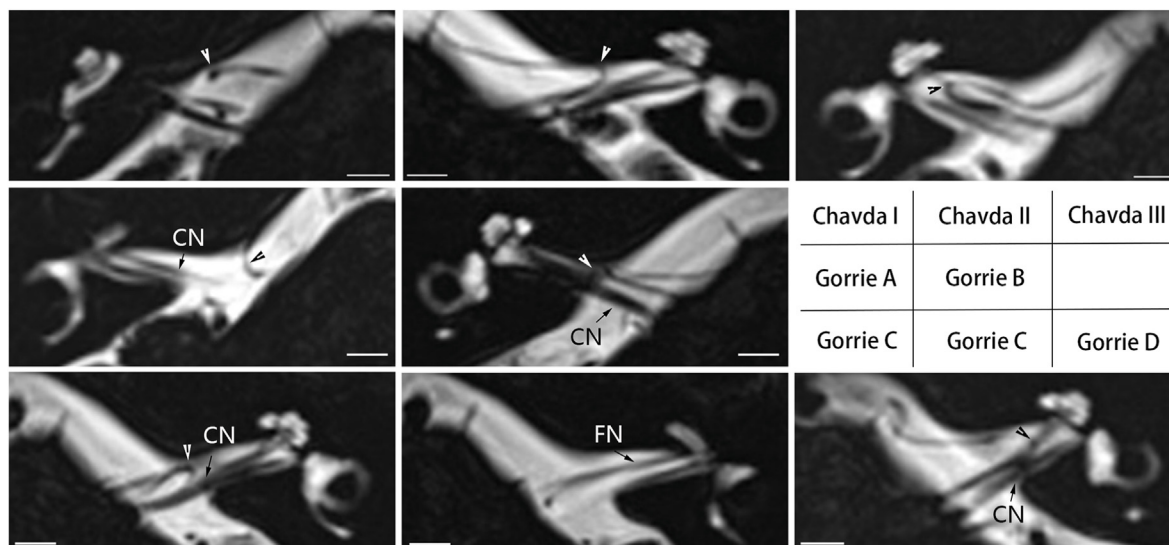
Representative MRI demonstrating the Chavda and Gorrie classifications of the anterior inferior cerebellar artery (AICA). The distal point of the AICA is indicated with an arrowhead. CN: cochlear nerve; FN: facial nerve. Scale bars = 5 mm.
